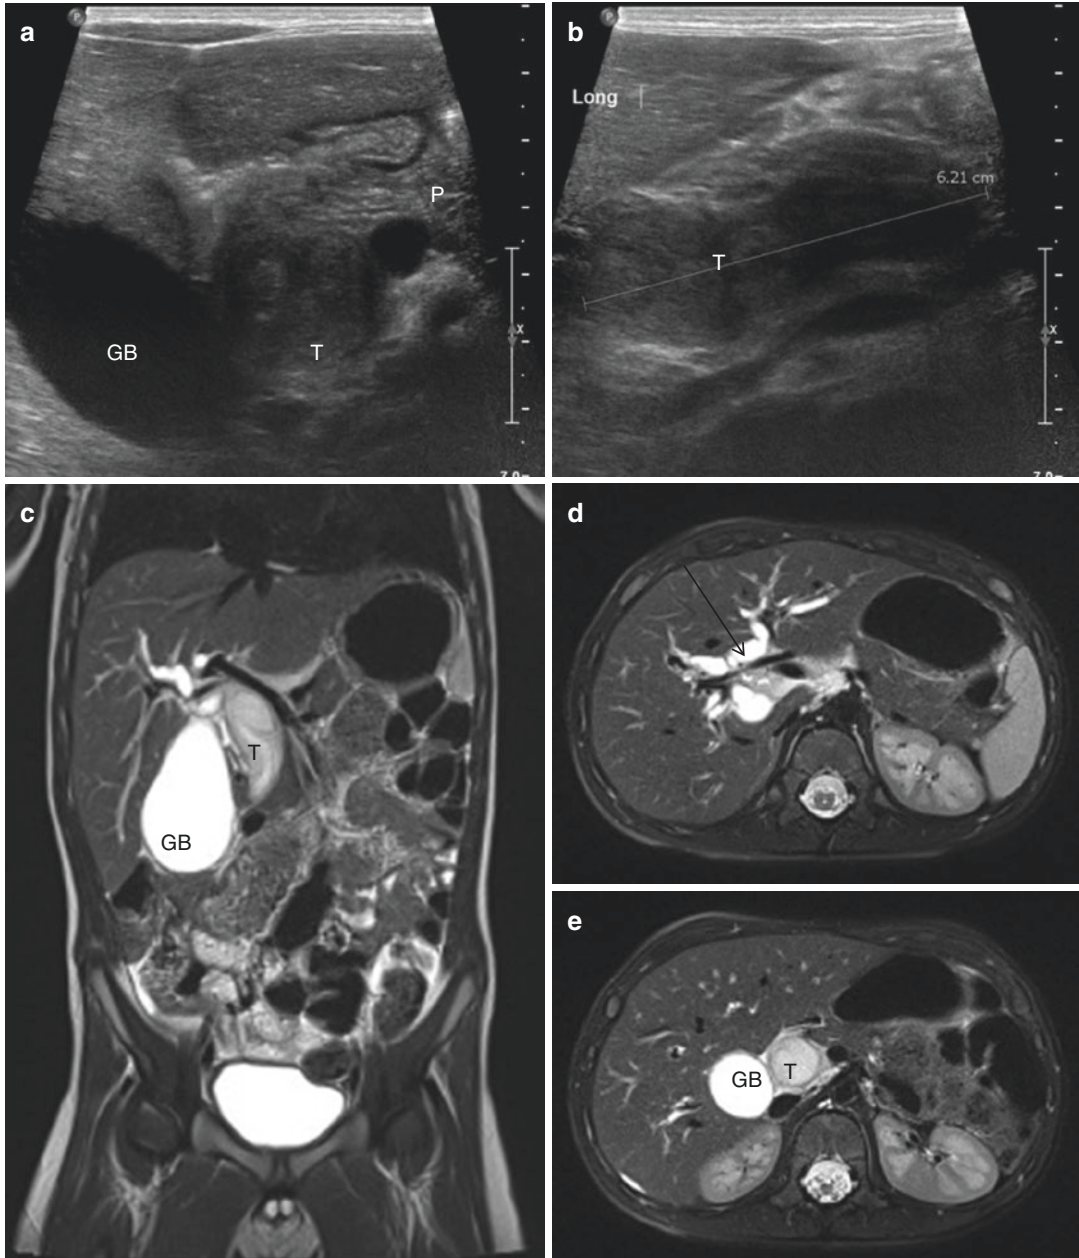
This 3-year-old boy presented with progressive jaundice since 5 days. Axial (a) and sagittal (b) abdominal US and coronal (c) and axial (d, e) fat saturated T2-weighted MRI show a mass (T) in the distal choledochal duct (gall bladder (GB) and pancreas (P))
